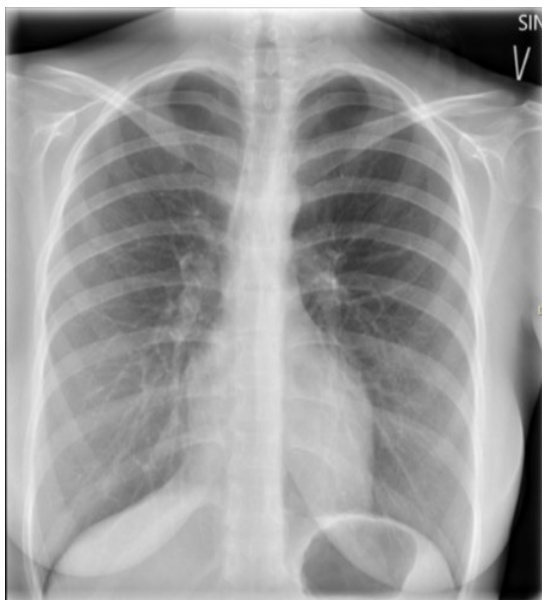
Chest X-ray post-surgical resection of the cyst, now displaying a normal heart silhouette.
